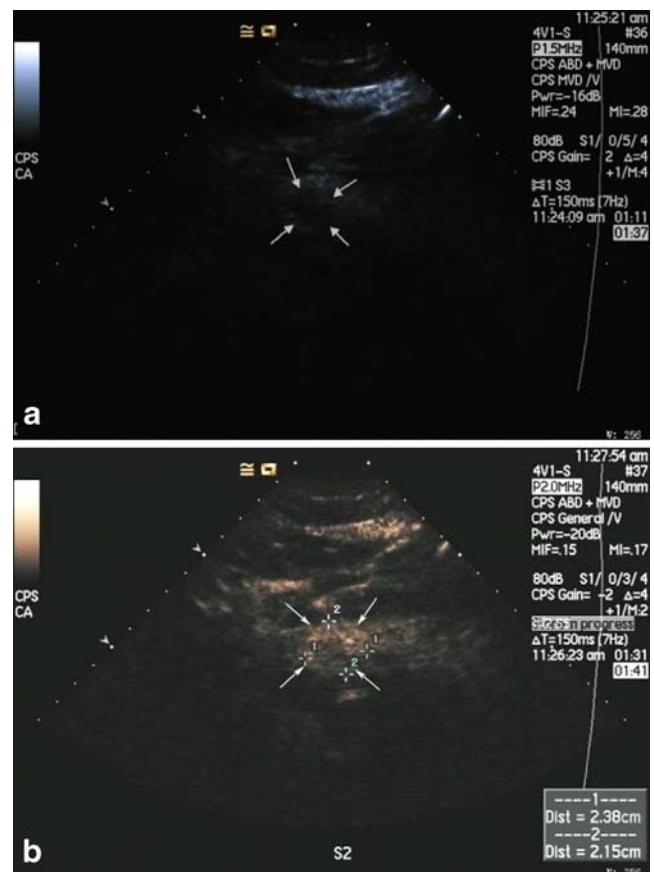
An insulinoma (arrows) located at the body of the pancreas, as shown by SonoVue-enhanced ultrasonography before (a) and after (b) contrast injection.
